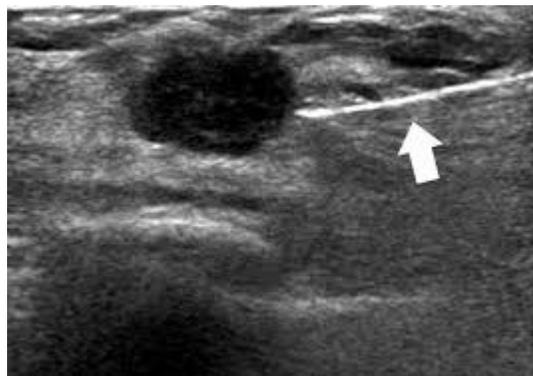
Needle being guided into an abscess under ultrasound guidance (Anmol)
